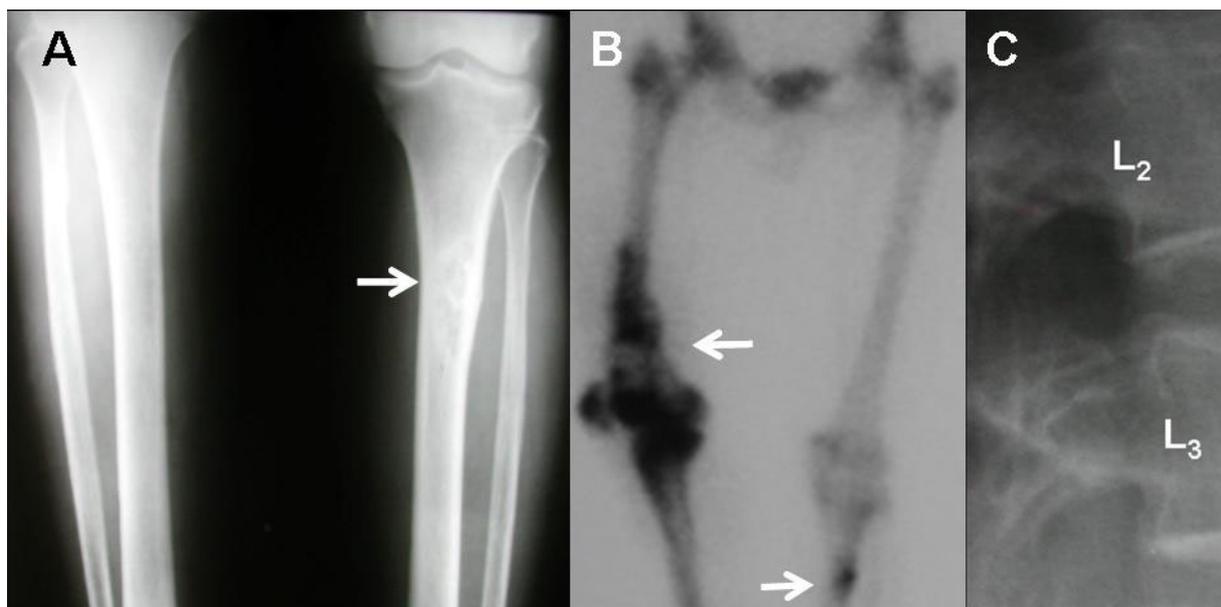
(A) Initial plain radiograph shows osteolytic lesions at the proximal and distal tibia (arrows). (B) Tc-99 bone scan shows increased uptake at right distal femur, knee, ankle and left proximal tibia (arrows). (C) Lateral view radiograph showing L3 vertebra metastatic lesion (arrow)
